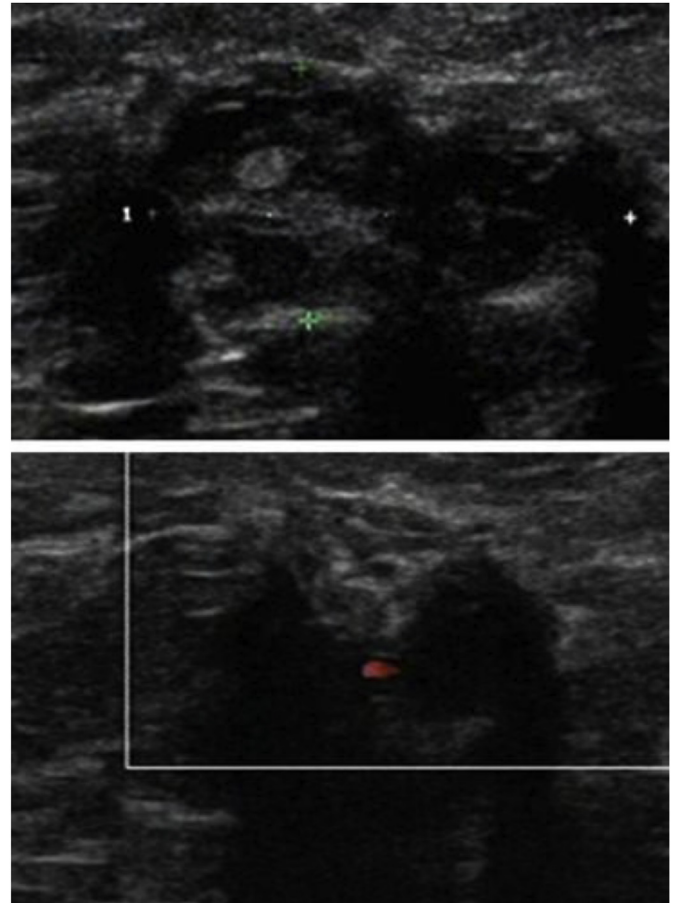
The two of nodes in the figure show some collapses and with some strip shaped hyperechogenic in them which made some ultrasonic decay.
